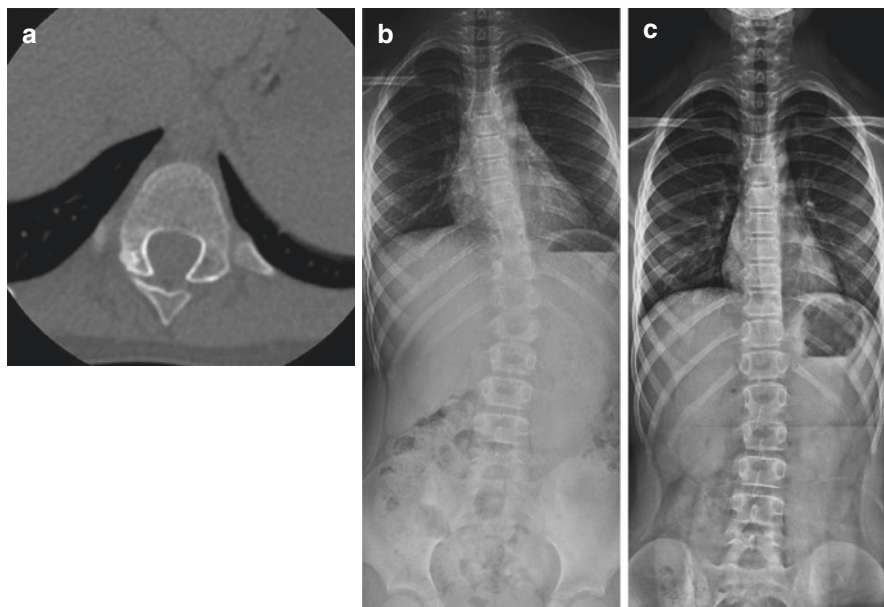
Scoliosis status post T11 osteoid osteoma resection in female patient: (a) Preoperative axial CT: it demonstrates osteoid osteoma in right super articular process of T11. Orange arrow indicates lesion. (b) Preoperative AP film: moderate left-sided curve measuring approximately 24° . Orange lines represent end vertebrae. (c) AP view film taken six months postoperatively: Resolved curvature
